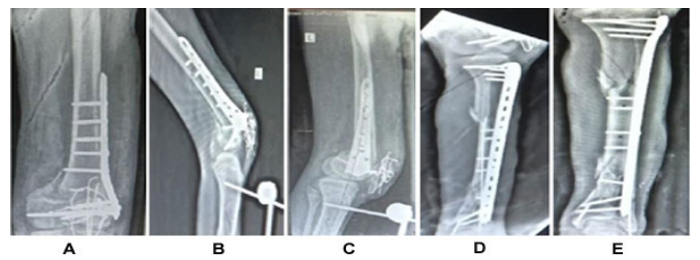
showing immediate postoperative radiographs. (A,B,C) – showing distal femur fracture fixation with distal femur locking plate with patellar TBW and encirclage. (D,E) showing tibial fracture fixation with long hockey plate done by minimally invasive percutaneous plate osteosynthesis (Mippo technique) and medial malleolus fracture fixed with CC screw , fibula fracture fixation done by 2.5 mm rush nail.
